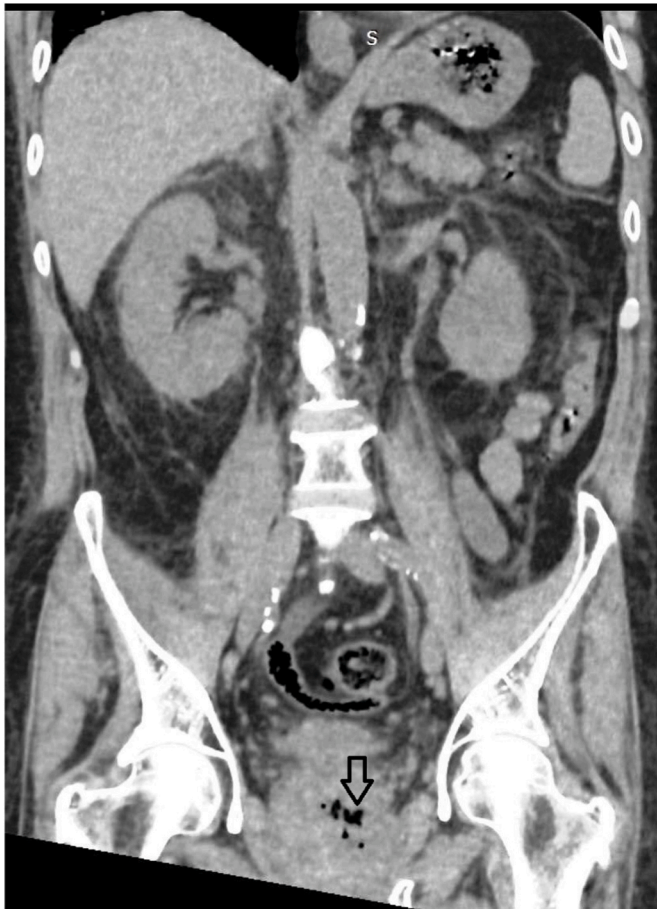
An abdominal non injected computed tomography showed a heterogeneous prostate with hypo dense infracentimetric collections and intraparenchymal air bubbles (Arrow), both kidneys were normal, with no dilatation of the excretory cavities.
